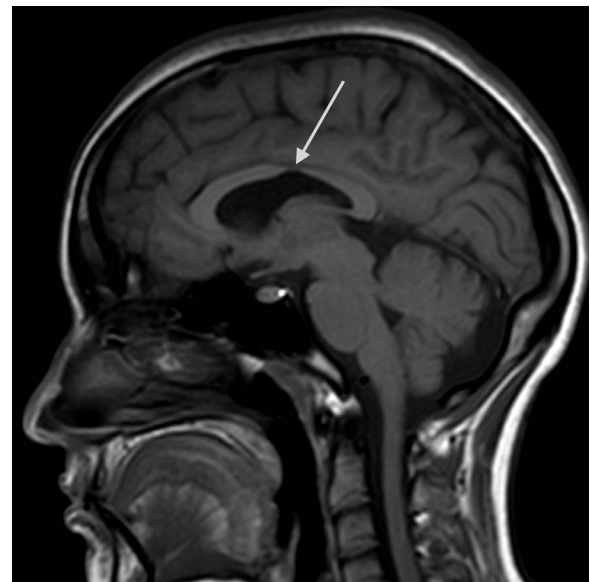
Midsagittal T1 weighted MRI image showing the focal thinning of the corpus callosum (white arrow).
